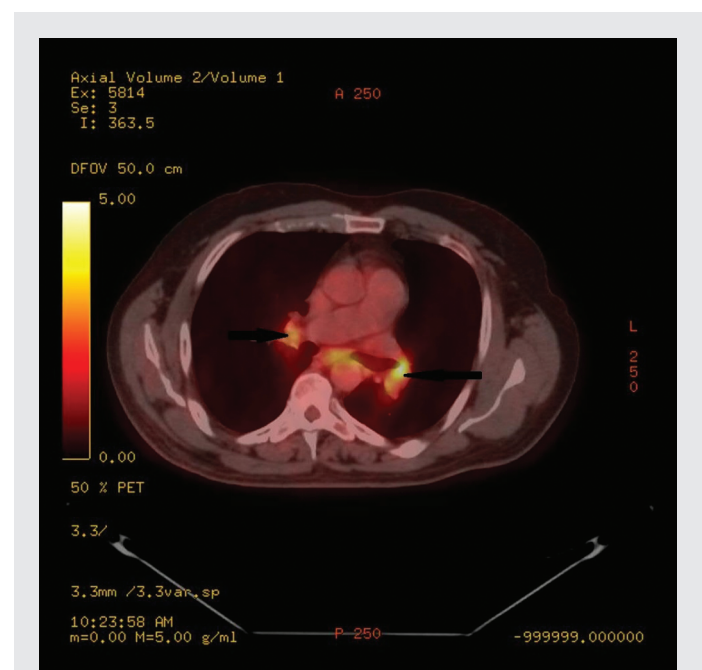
Pre-operative bilateral lymphadenopathy: PET/CT image showing bilateral mediastinal lymphadenopathy (indicated by arrows). PET shows SUVs between 4 and 6.5. These were initially worrisome for metastasis of the primary tumor; however, pathology did not show any evidence of malignancy but did show mixed dust deposition and non-caseating granulomas.
